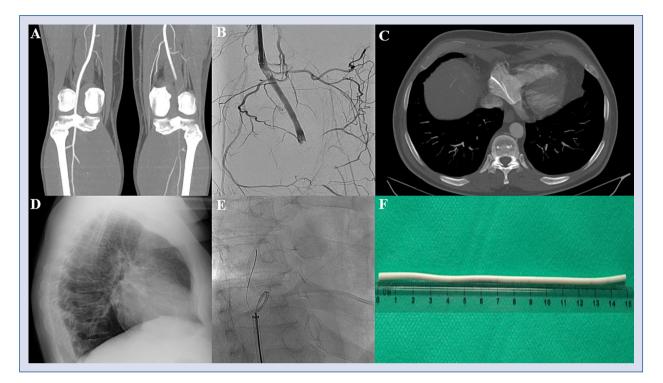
A. Computed tomography angiography — complete occlusion of the left popliteal artery; B. Angiography-complete occlusion of the left popliteal artery; C. Chest computed tomography-fractured fragment of a central venous catheter in the right atrium; D. Chest X-ray-fractured fragment of a central venous catheter in the right atrium;
